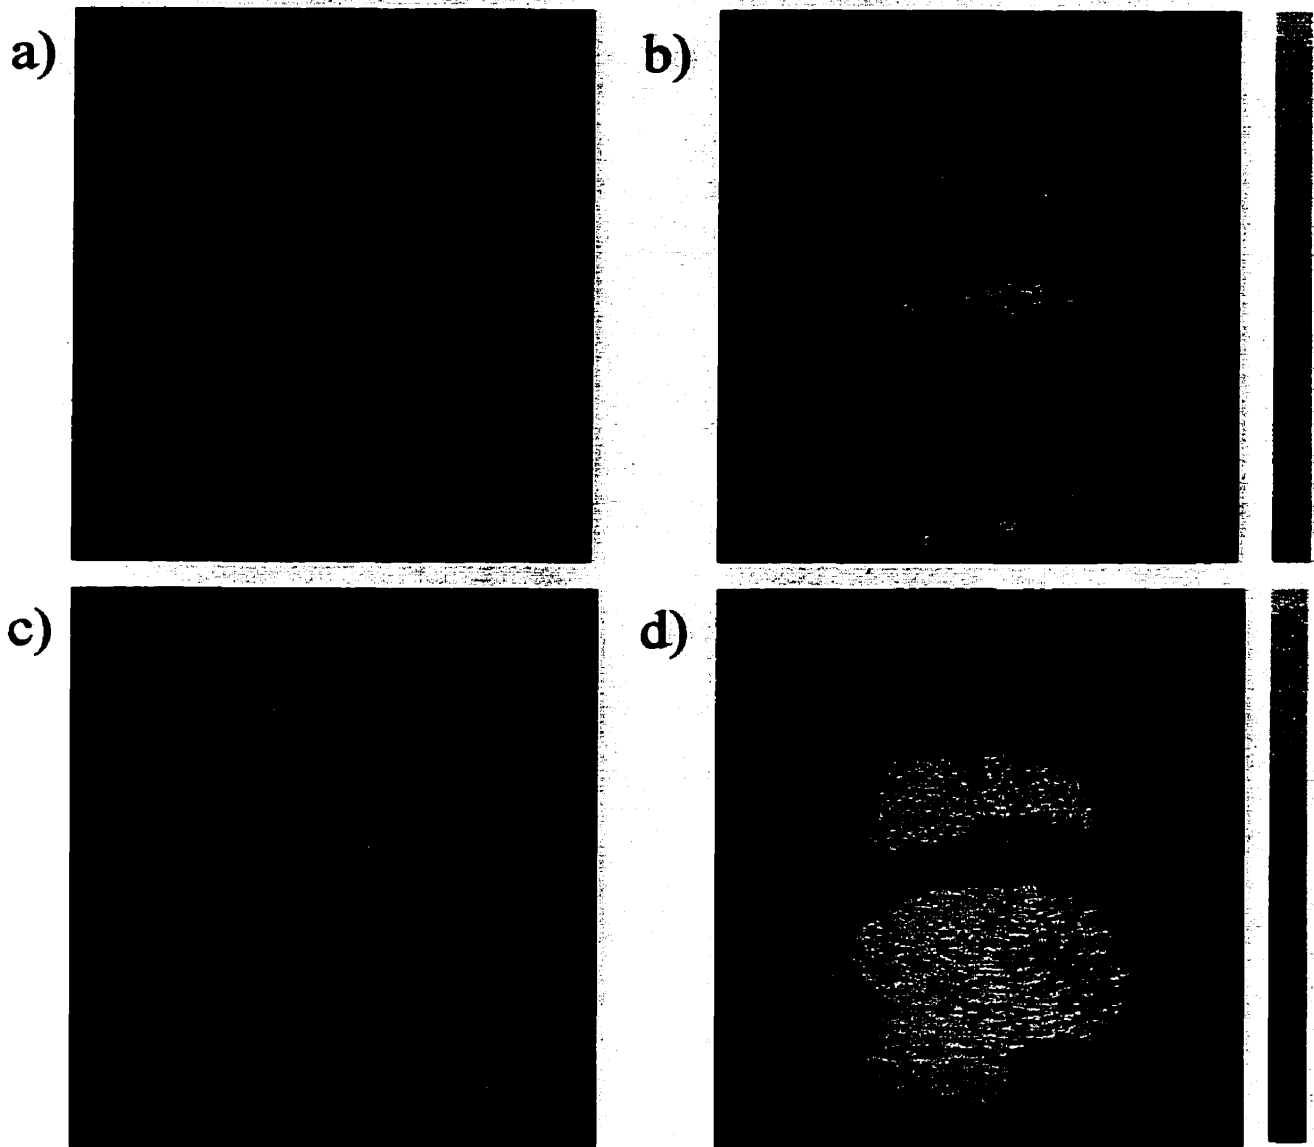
Right parasternal short axis images of the heart made with 11-pulse pulse inversion Doppler at a frame rate of 1 frame per 3 heartbeats: a) baseline image at $MI=0.2$; b) following a bolus injection of $20 \mu\text{l kg}^{-1}$ of Optison at $MI=0.2$; c) baseline image at $MI=1.0$; d) following a bolus injection of $20 \mu\text{l kg}^{-1}$ of Optison at $MI=1.0$. In all images the dynamic range of the colour overlay is 40 dB. Pulse inversion Doppler can detect myocardial perfusion at both low and high incident pressures.
